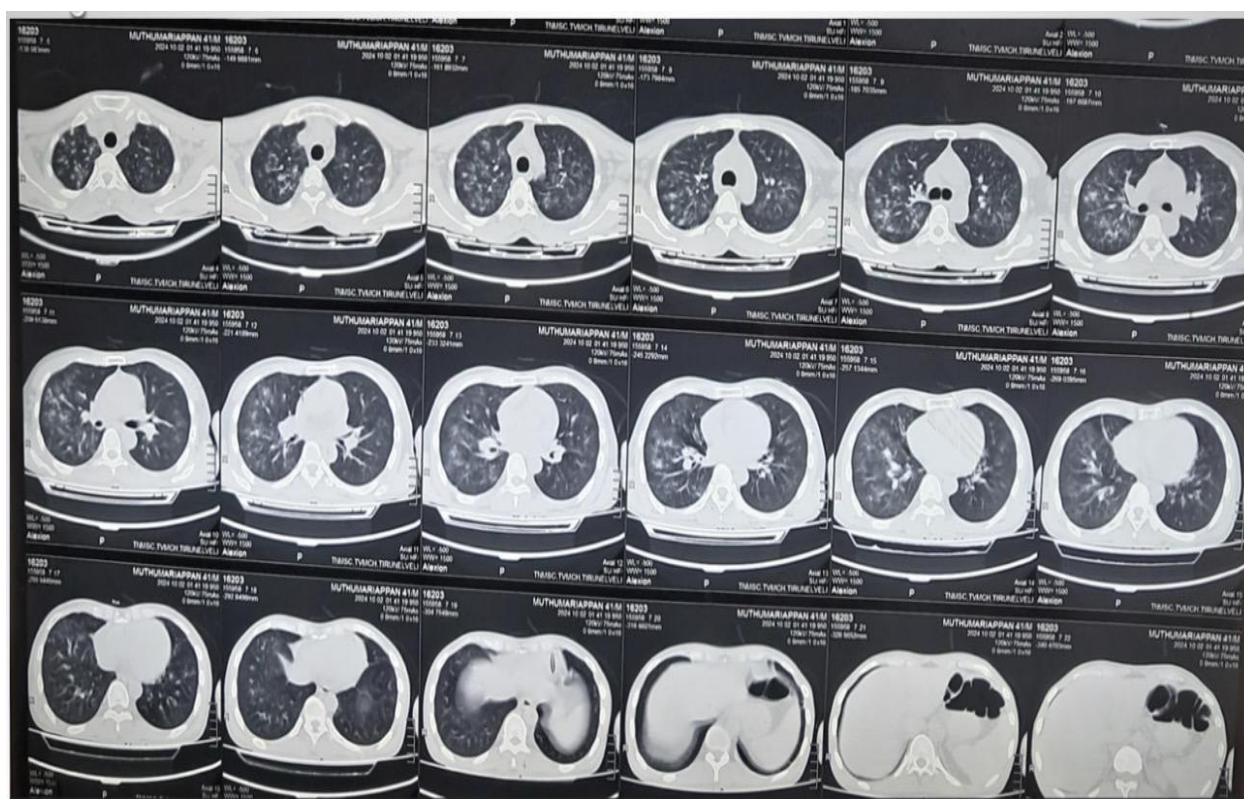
CT chest showing centrilobular nodules and ground-glass opacities in bilateral upper lobes suggestive of pulmonary vasculitis.
